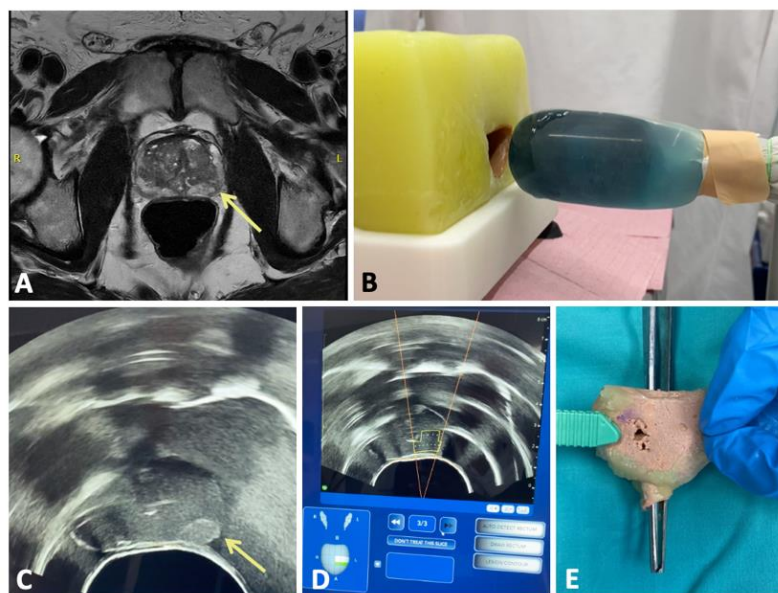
(A) Preoperative mpMRI images with the 1.1cm left mid/base peripheral zone lesion; (B) the insertion of the Focal One[®] probe into the patient-specific 3D printed Hydrogel-based model; (C) sonographic appearance of the model prostate with the lesion also visualized; (D) the ablative treatment applied to the 3D model with the treated area contoured in blue; (E) the dissection following ablative treatment of the 3D model showcasing the hollowed appearance of the targeted area compared to the smooth appearance of the non-treated area.
